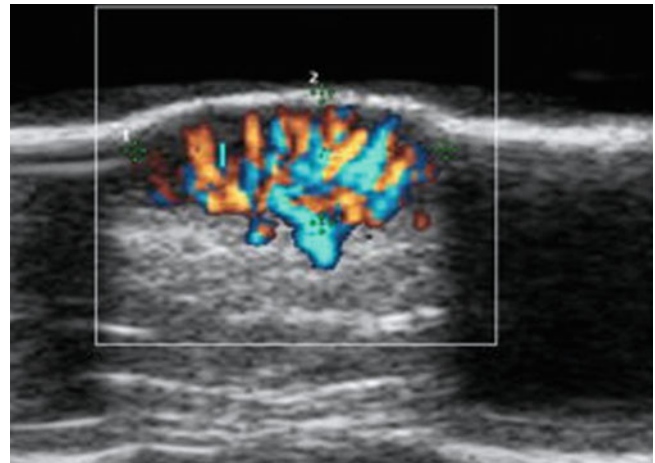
Primary melanoma. Directional power Doppler image. Vascularization shown at the basis of the lesion. Tumor thickness is 4 mm
